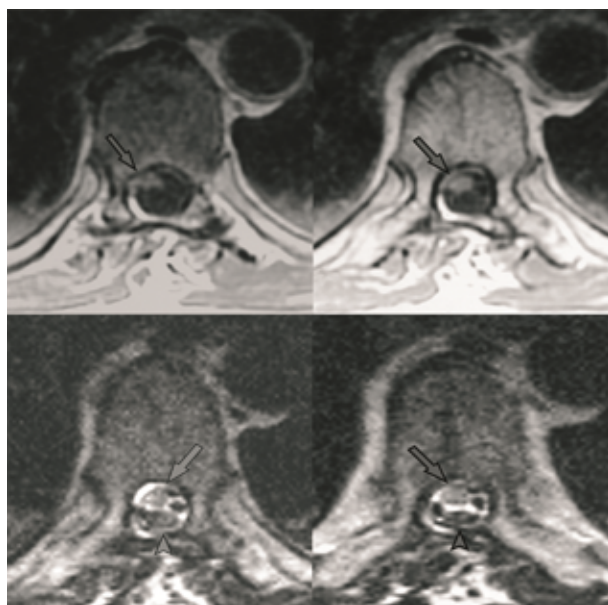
Axial enhanced T1-weighted MR images showing a focal atrophy of the spinal cord at the D7 level with the typical mushroom-shaped herniation through the dura mater.
